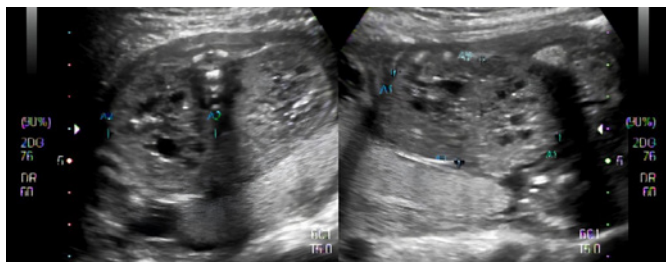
Two-dimensional ultrasound images taken at 22 weeks of gestation, showing the appearance of the kidneys, which are dysplastic and enlarged, as well as hyperechoic, with multiple cysts inside and poor corticomedullary differentiation.
